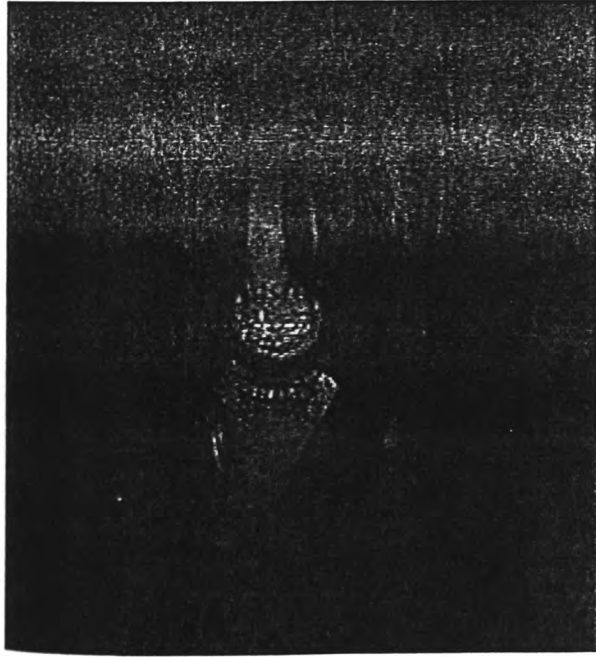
MRI finger scan.
